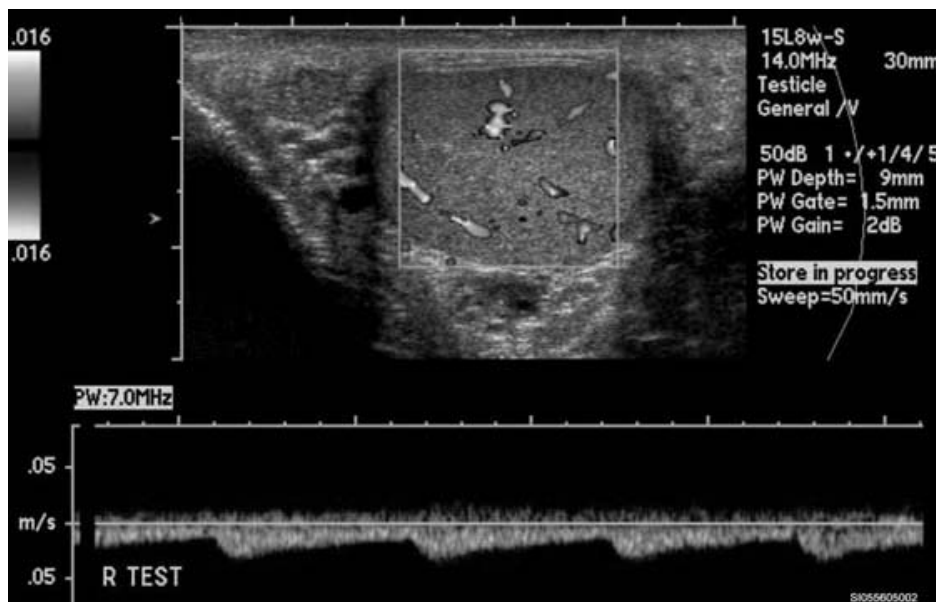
Arterial flow in the testis on spectral Doppler.
